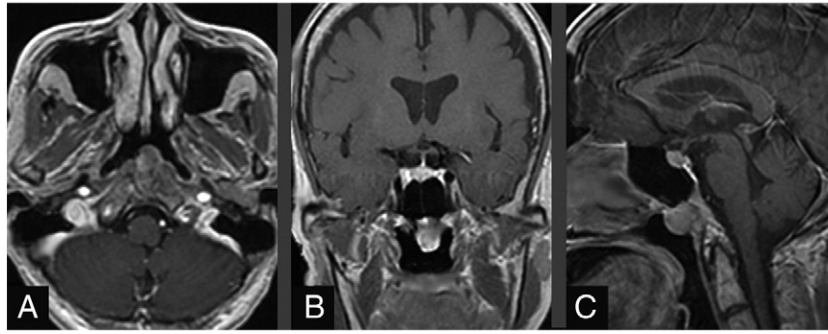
Pre-treatment MRI. (A) Axial, (B) coronal, and (C) sagittal T1-weighted MRI with contrast showing the clival lesion (white arrows) protruding into the nasopharynx. The lesion measures 1.8 cm × 1.35 cm × 1.3 cm at its widest diameters.
